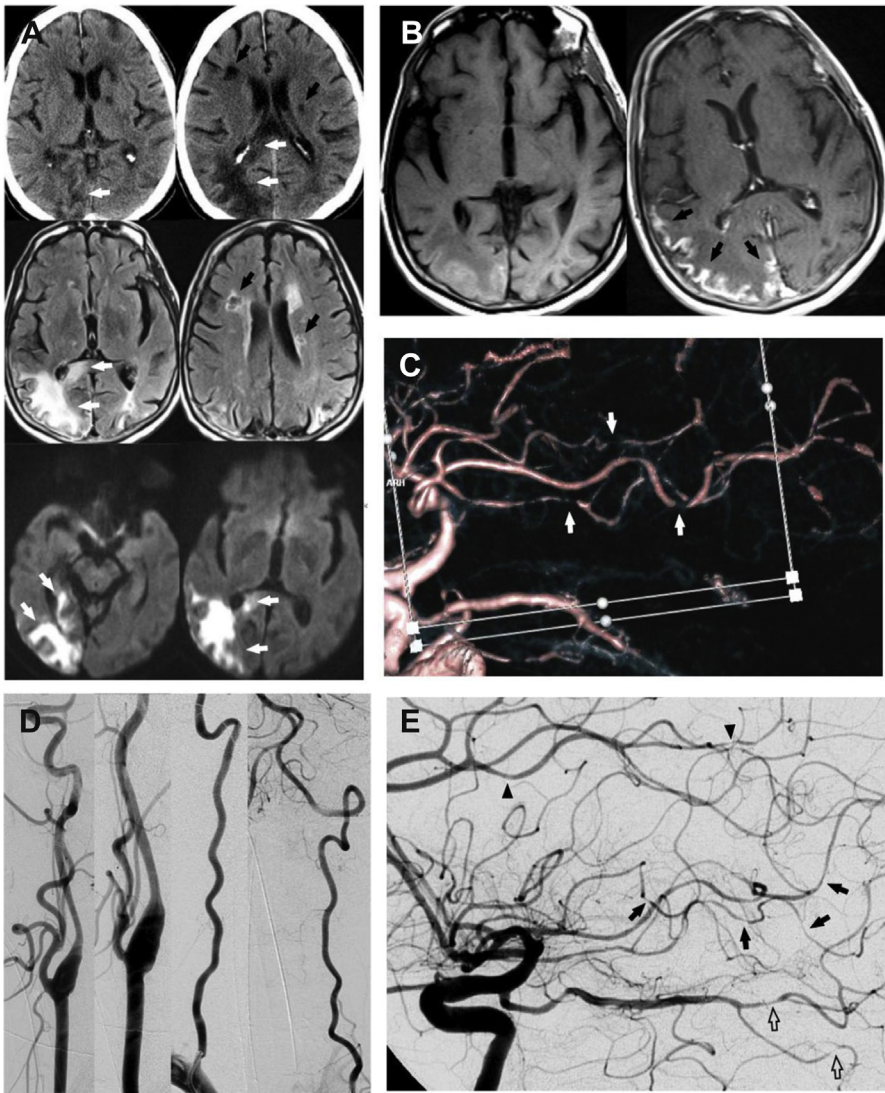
PACNS. (A) Noncontrast CT (*top*) demonstrates multifocal regions of low attenuation. Those in the right frontal subcortical white matter and left basal ganglia (*black arrows*) are sharply defined, without mass effect and likely reflect old infarctions. Both the cortex and underlying white matter of the right occipital lobe are involved, as is the right splenium of the corpus callosum (*white arrows*). In these locations, the margins are more ill-defined and there is subtle mass effect characterized by sulcal and ventricular effacement, suggesting acute ischemia in the right PCA territory. MRI FLAIR imaging (*middle*) demonstrates central low and peripheral high signal intensity within the frontal and periventricular white matter lesions (*black arrows*) consistent with chronic encephalomalacia from old infarctions. The FLAIR hyperintense signal within the right occipital lobe is more confluent and extends to the posterior temporal lobe and splenium, involving both cortex and white matter (*white arrows*) and better delineates the extent of the acute infarct. DWI (*bottom*) demonstrates restricted diffusion consistent with acute ischemia. (B) T₁-weighted imaging before and after gadolinium demonstrates extensive leptomeningeal enhancement along
